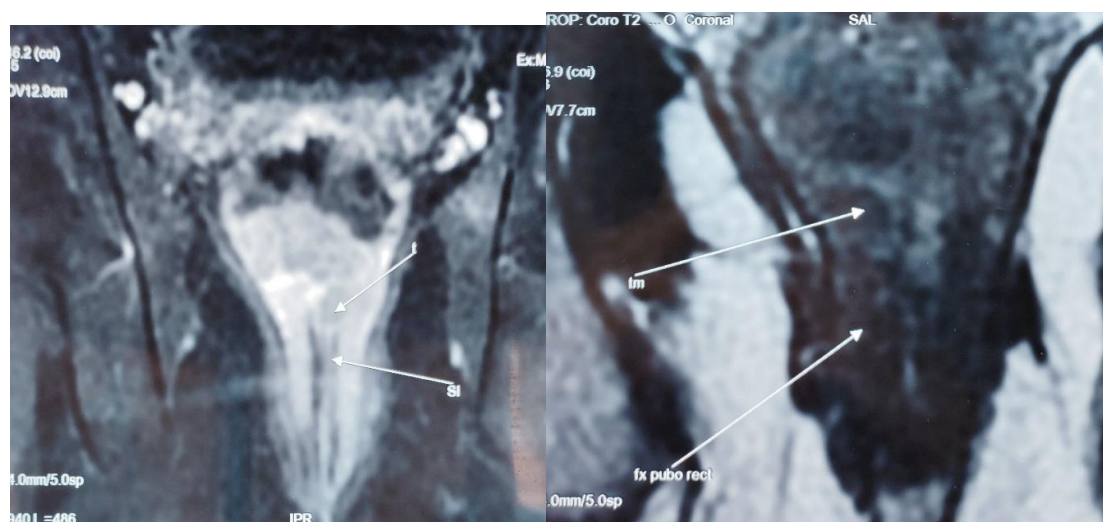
Pelvic MRI: frontal view, showing a rectal tumor (t) infiltrating the internal sphincter.
